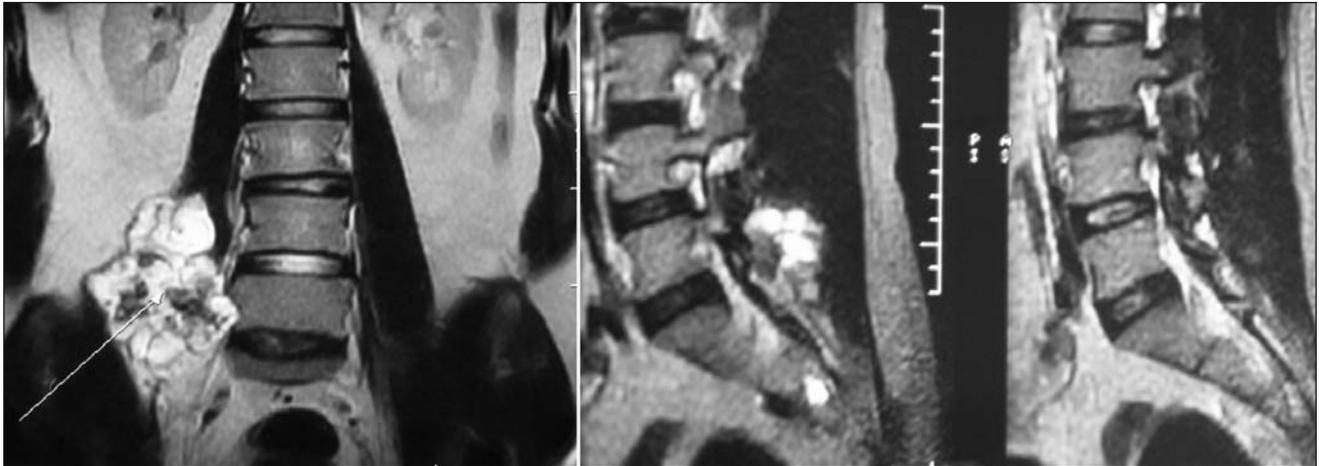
Magnetic resonance imaging showing the sacral origin of sharply delineated lobular swelling (arrow). The mass was iso- to hyperintense on the T_1 -weighted image and hypointense on the T_2 -weighted image.
